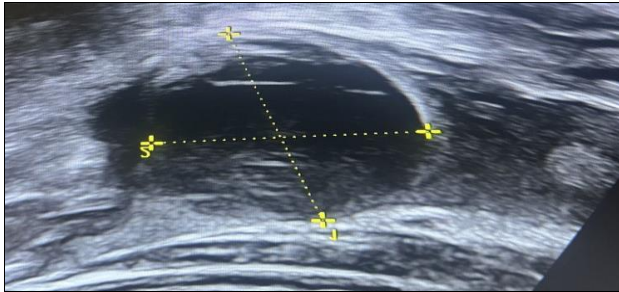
A 19-year-old female patient's transabdominal sonography revealed a right ovarian cyst with internal echoes, suggesting a hemorrhagic cyst. The patient also reported right iliac fossa pain.
